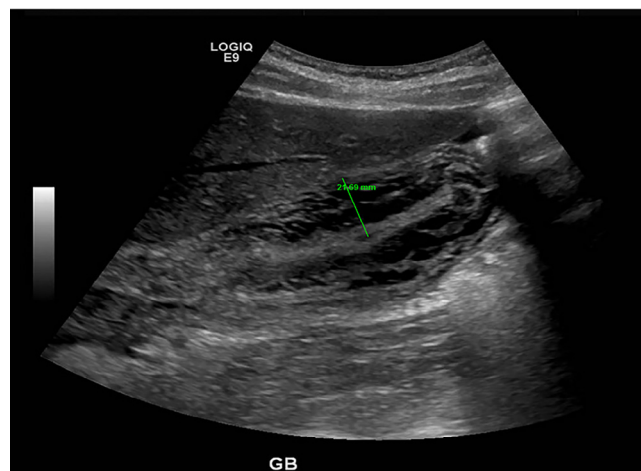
Ultrasound scan demonstrating marked gallbladder wall thickening (21 mm) and a collapsed lumen.
